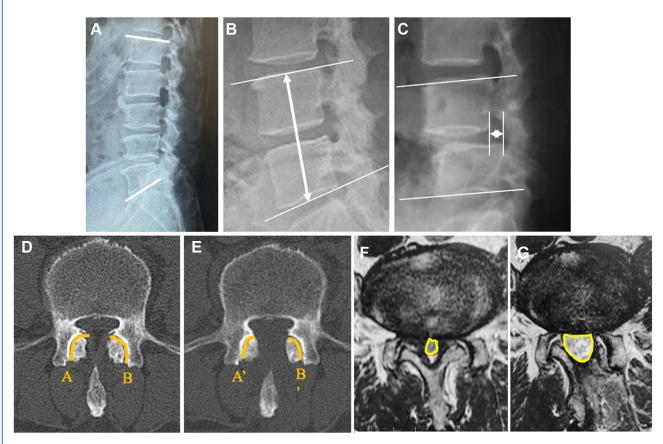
Lumbar lordosis was measured as the angle between the superior endplates of L1 and S1 using an upright lateral radiograph (A). The range of motion of lumbar lordosis was calculated from the flexion—extension radiograph. The functional spinal unit consisted of 2 adjacent vertebrae and an intervening intervertebral disc (B). The height and segmental angle of the functional spinal unit at the operated segments were measured from an upright lateral radiograph. The flexion angle and anterior slip of the vertebral body at the operated segments on an upright flexion radiograph were measured preoperatively and at 1 year postoperatively for those with Meyerding grade 1 spondylolisthesis (C).
